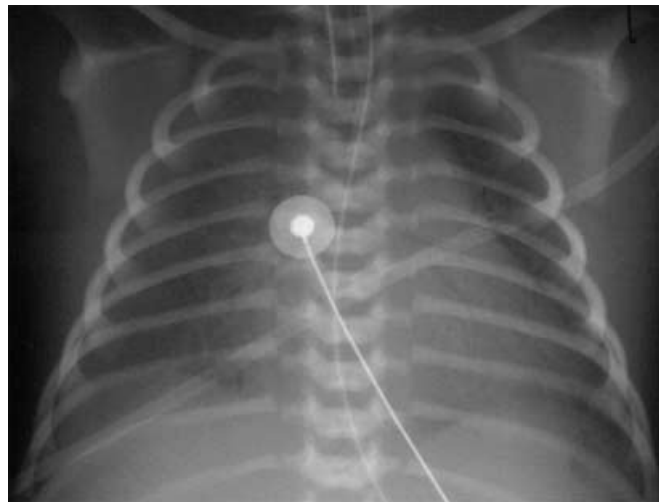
Chest X-ray film of a 2-hour-old preterm baby (infant 4) with RDS. The radiographic examination was performed 6 h before the first EIT measurement shown in Fig. 5
